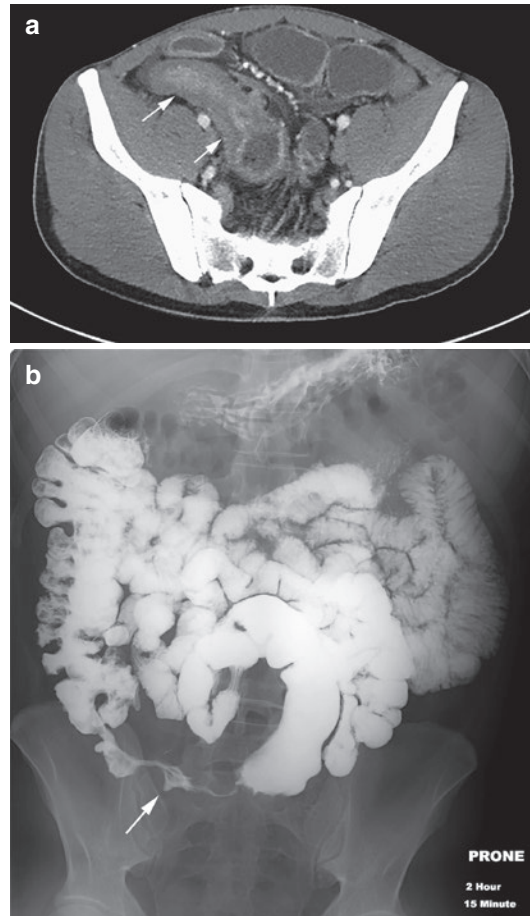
(a) A 45-year-old female with history of Crohn's disease presents with worsening right lower quadrant abdominal pain. Axial CT demonstrates marked mural wall thickening of the terminal ileum and luminal narrowing consistent with terminal ileitis (arrows). (b) Different patient, 38-year-old with history of Crohn's disease, underwent fluoroscopic small-bowel follow-through series demonstrating marked luminal narrowing and fibrosis of an 8–9 cm segment of terminal ileum consistent with a "string sign"
